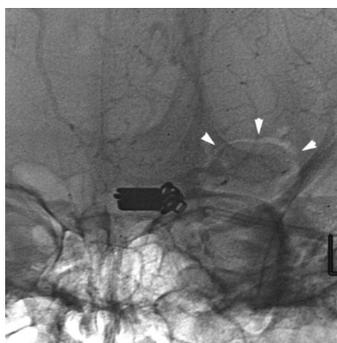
Postoperative x-ray showing the relationship between the aneurysm clips and the limited left-sided craniotomy (arrowheads).
